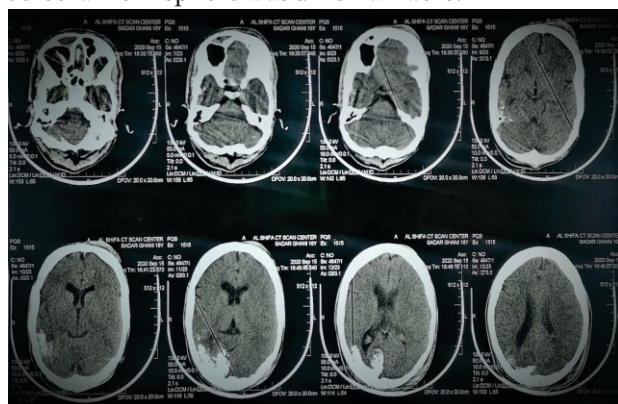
CT scan showing cortical and subcortical calcifications involving right temporal and occipitoparietal regions.
